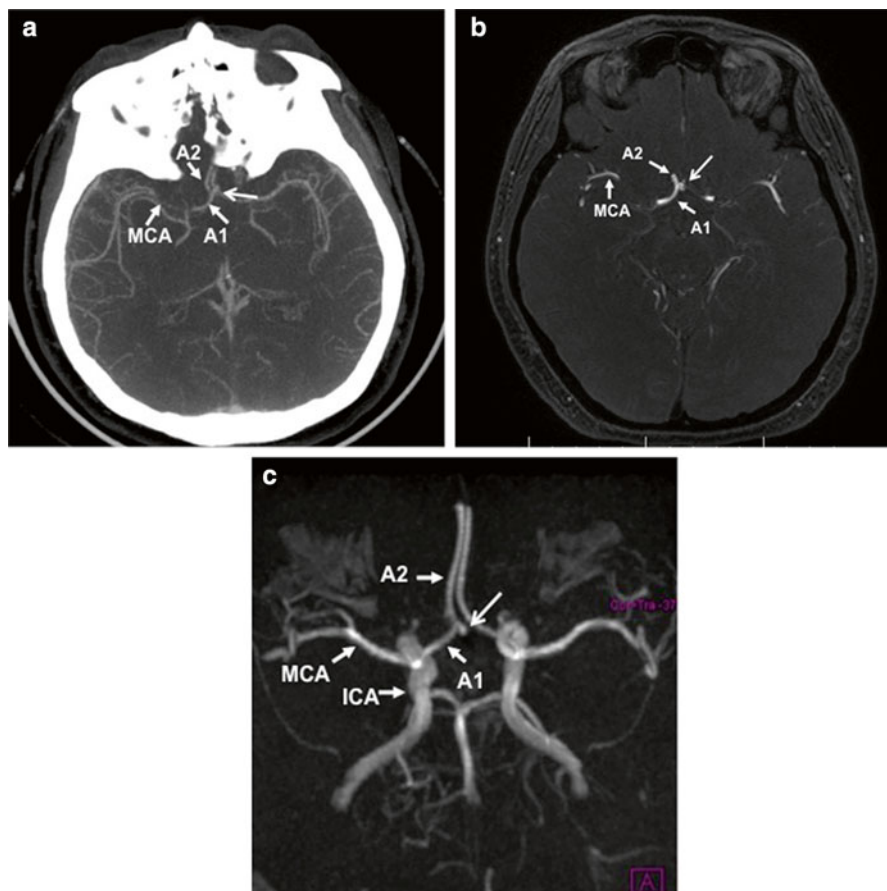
Management of residual aneurysm sac after endovascular coiling. Forty-two-year-old female with anterior communicating artery aneurysm indicated for endovascular coiling. A tiny residual aneurysm was revealed on MRI control scanning 6 months after the procedure (conservative approach with regular MRI controls was recommended). (*top left*) CT angiography showing the aneurysm (*open arrow*) of the right anterior communicating artery (*top right*) MR angiography revealing a residual filling of the aneurysm (*open arrow*), size of 2 mm (*bottom*) MRA angiography reconstruction of the circle of Willis. A1 A1 segment of the anterior cerebral artery, A2 A2 segment of the anterior cerebral artery, ICA internal carotid artery, MCA middle cerebral artery
